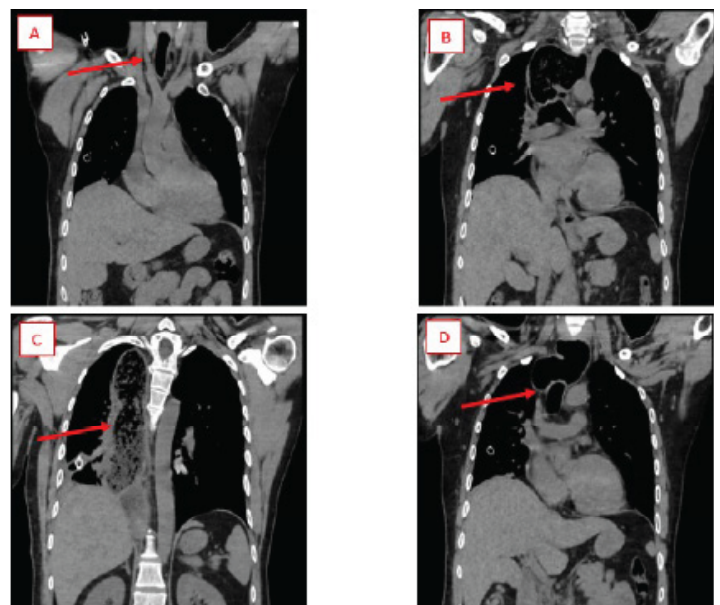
A: Coronal computed tomography (CT) chest demonstrating patent proximal trachea. B: Coronal CT chest demonstrating compressed carina with deviation of mid-trachea to the left. C: Coronal CT chest demonstrating continued esophageal dilation with food content. D: Coronal CT chest demonstrating dilated esophagus overlying a patent, non-deviated trachea.
